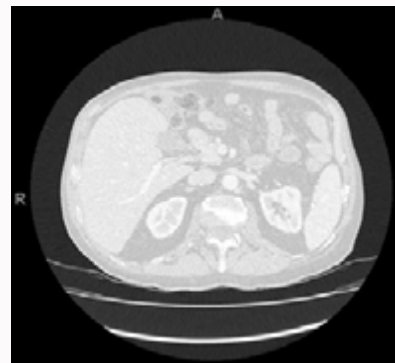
Abdominal CT-scan showing right colonic angle pneumatosis cysts and pneumoperitoneum at initial time of diagnosis.
